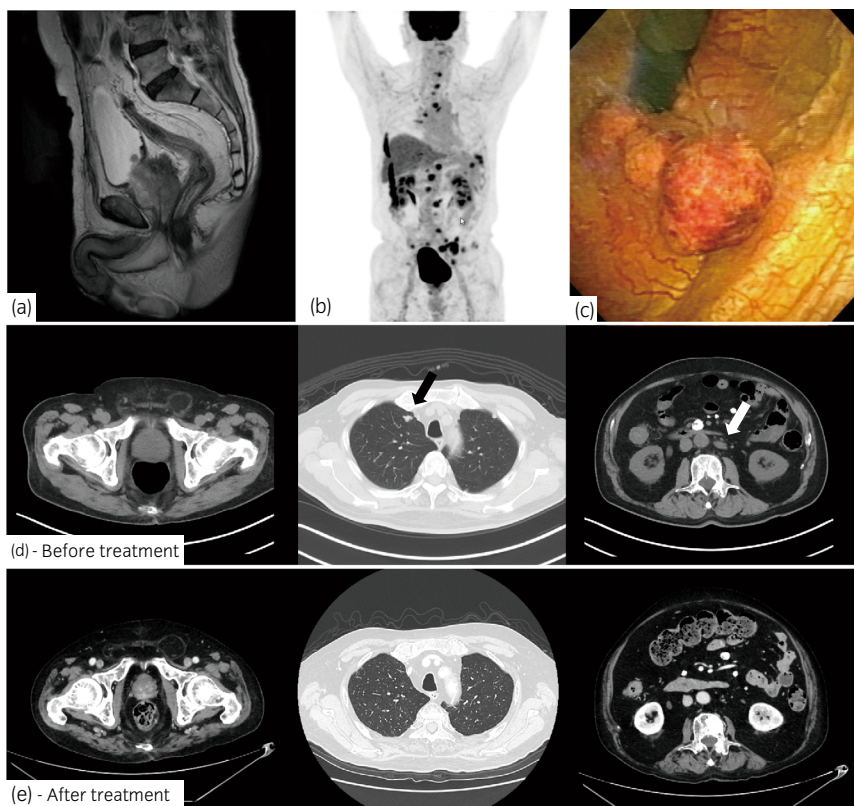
Imaging studies. (a) MRI revealed a prostatic tumor protruding into the bladder, with seminal vesicle invasion, and (b) positron emission tomography revealed multiple metastases to the para-aortic lymph nodes, bones, and bilateral lung. (c) Cystoscopy revealed a non-papillary tumor on the bladder neck. CT (d) before and (e) after treatment (10 months after completing 10 cycles of chemotherapy with etoposide and cisplatin) showed a partial response to both primary and metastatic lesions (arrow).
